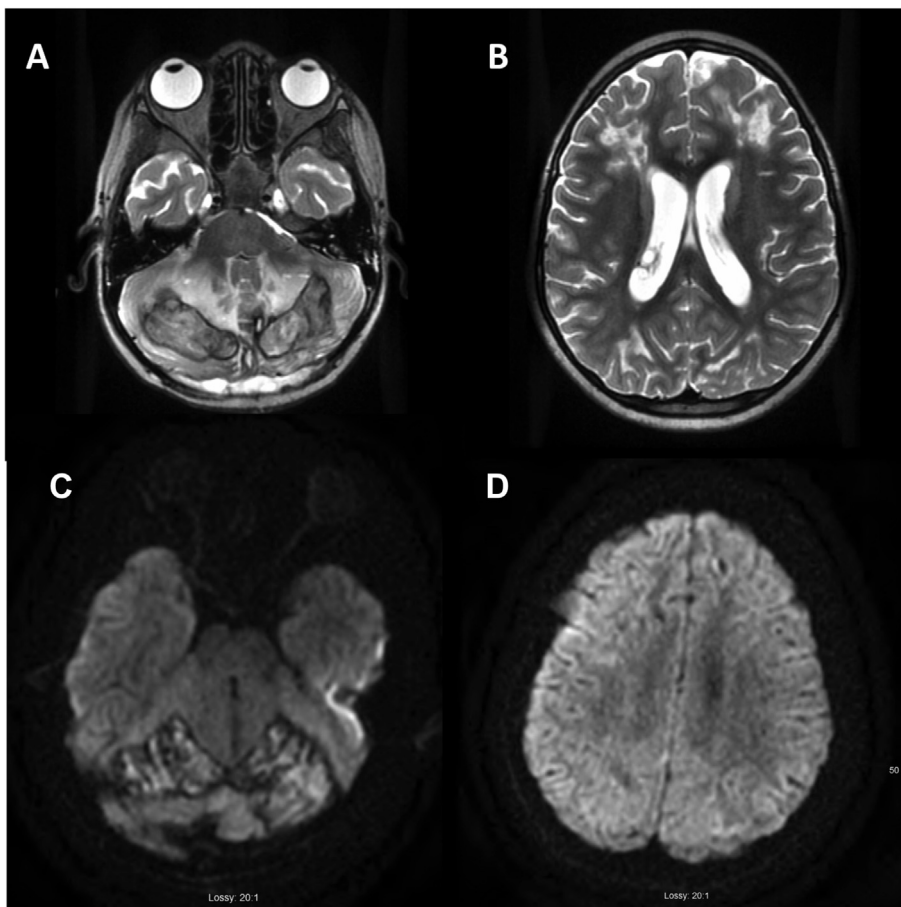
Delayed MRI 28 days after presentation after poor neurological examination persisted (A,B) and 20 days after presentation (C, D). A) Axial T2-weighted image showing less brainstem compression, B) Axial T2 image showing ventriculomegaly without elevated ICPs with resolution of sulcal effacement C) Axial DWI showing interval improvement of swelling of the cerebellum with significant decrease in degree of effacement of ventricles D) Axial DWI showing interval improvement of signal abnormality within the cerebellum and cerebrum.
